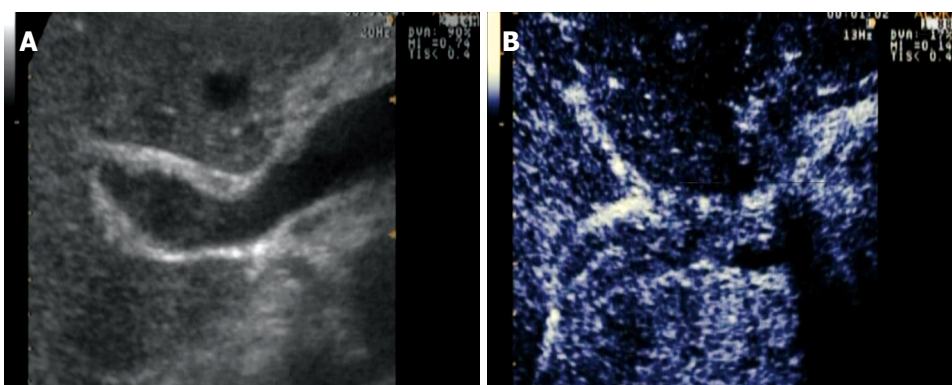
Malignant thrombus. A: sonography reveals echogenic area (thrombus) within vessel lumen; B: during arterial phase of contrast-enhanced sonography the diffusely enhanced area representing thrombus with internal neovascularity.
